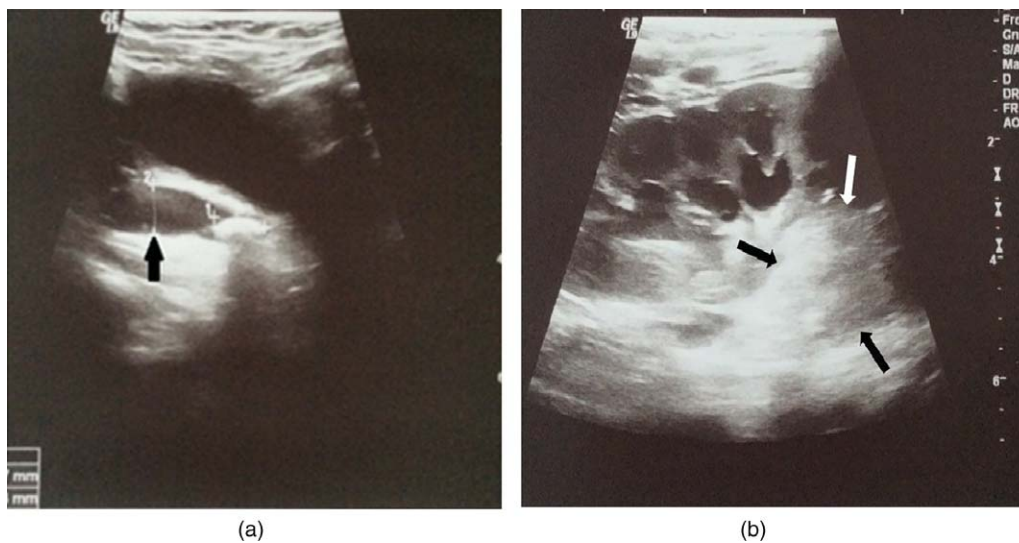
a,b. (a) Parasagittal sonography through the urinary bladder reveals an ureteral stone just before the ureterovesical junction (arrow) and proximal ureteral dilatation. (b) Coronal ultrasonography shows a well-defined cortical hyperechogenic area at the upper pole of the left kidney (arrows). Collecting system is also dilated
